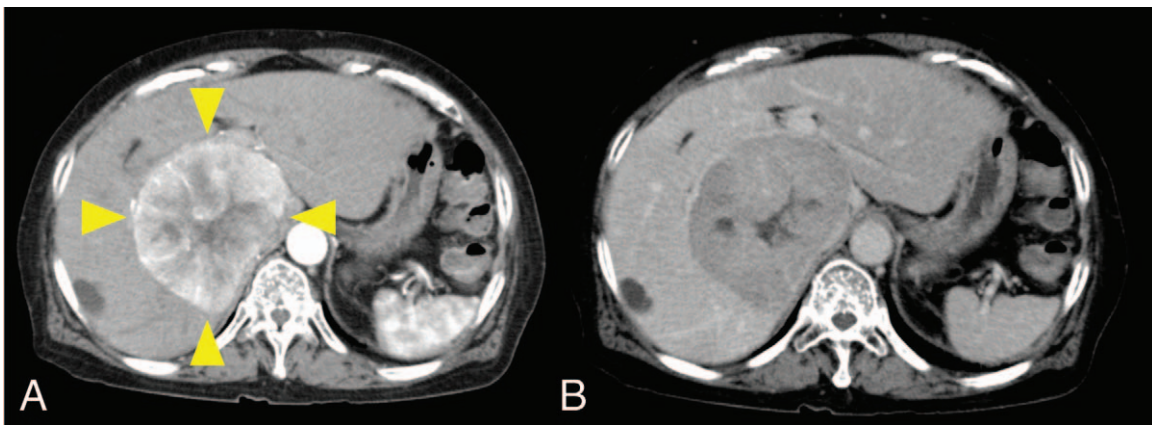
Contrast-enhanced computed tomography. (A) Arterial phase. (B) Delayed phase. A large tumor with early arterial enhancement and delayed phase washout is present in the right lobe of the liver (arrowheads).
